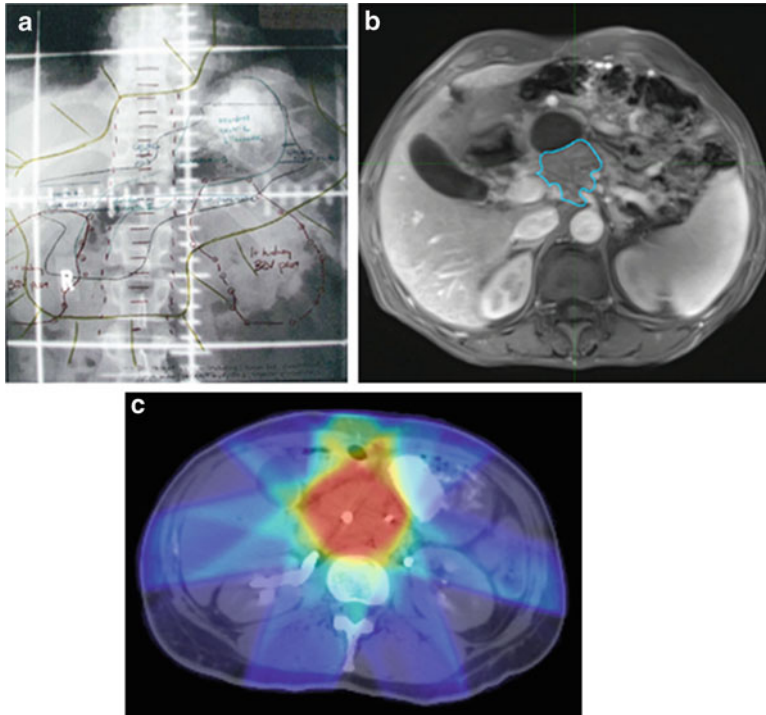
(a) Represents a historic radiation treatment plan using 2D planning techniques, little ability to visualize normal structures or adapt dose accordingly. (b) Reflects modern era tumor contouring using MRI. (c) Radiation dose deposition (red represents high/prescription dose, blue represents lower radiation dose). Structures such as the small bowel and kidney can be seen clearly and avoided
